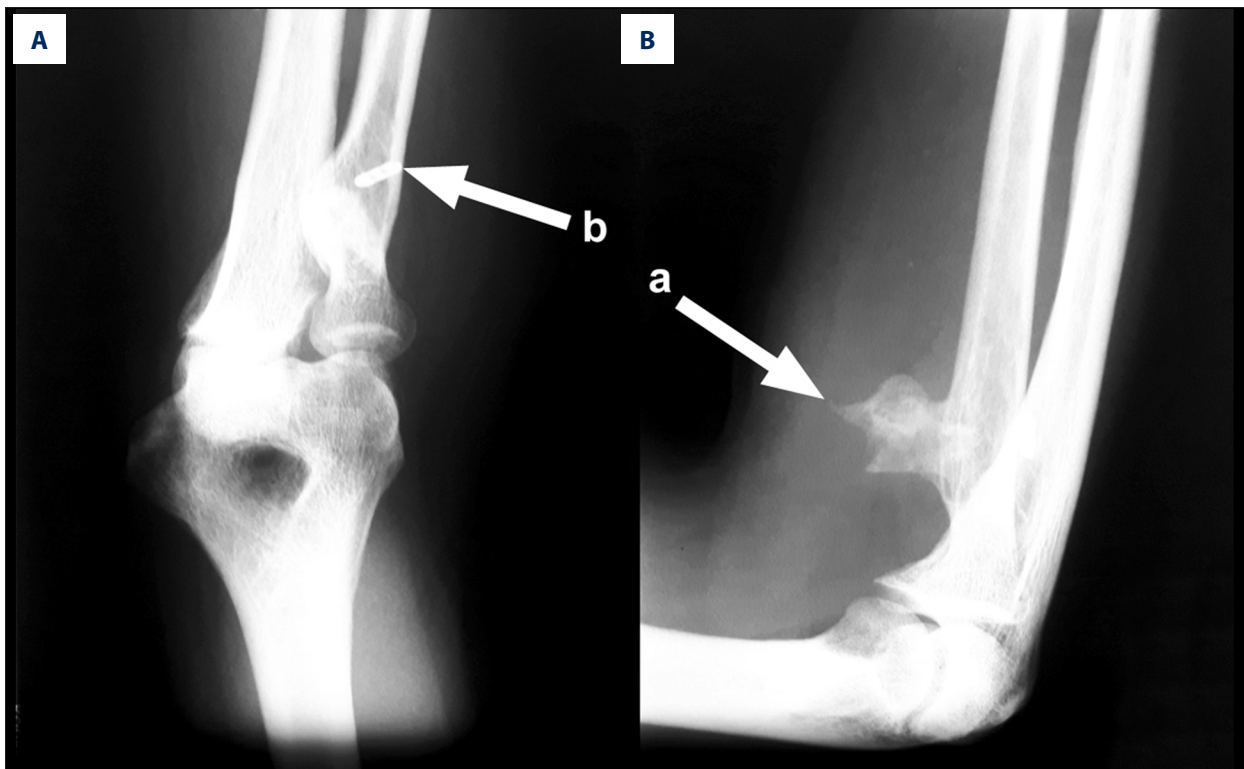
Antero-posterior (A) and lateral (B) radiographs of the elbow joint and proximal forearm after the surgical anatomical reinsertion of a ruptured distal biceps brachii tendon. The radiographs show heterotopic ossification, which is characterized by the formation of mature lamellar bone in no osseous location.
